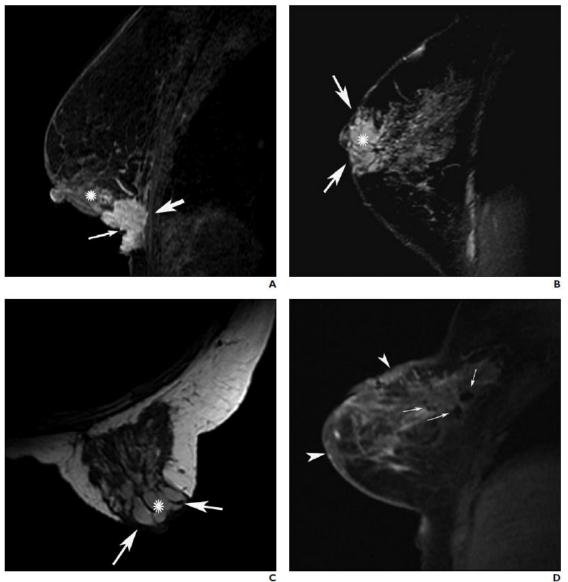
[27]: Images of the associated findings category of the BI-RADS MRI lexicon. Image A shows pectoralis muscle or chest wall invasion (thick arrow), skin involvement (thin arrow), and reticular enhancement (asterisk) in a woman with T4 breast cancer. Images B and C show unenhanced high signal intensity in ducts. Sagittal T2 (B) and axial T1 (C) images show subareolar dilated ducts (arrows) with areas of high signal intensity (asterisks). These areas represent benign ectatic ducts containing secretion with increased protein content. Image D of right breast after right segmentectomy for invasive ductal cancer shows abnormal signal voids (arrows) that denotes surgical clips. Deformity and skin thickening (arrowheads) due to surgery and radiation are evident.
